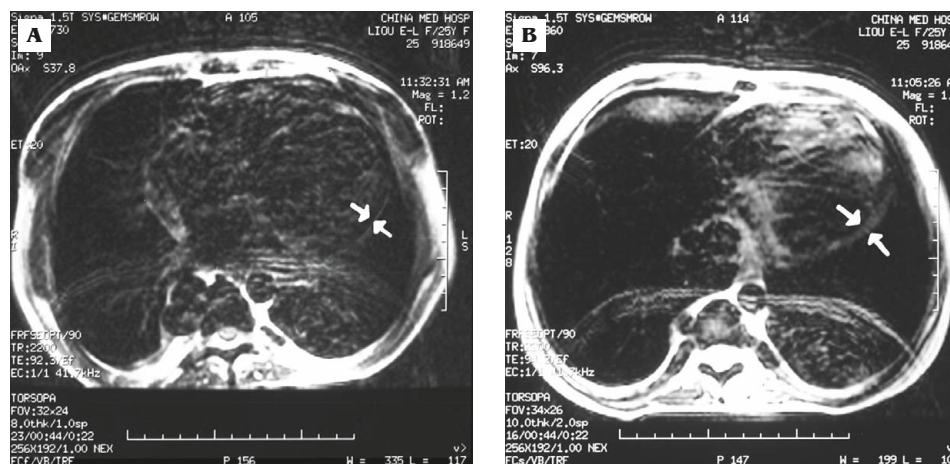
Magnetic resonance imaging of a patient's heart: (A) before combined therapy, axial view of the heart shows a decrease in signal intensity (SI) in the myocardium, suggesting substantial iron deposition (between arrows); (B) 13 months after combined therapy, marked recovery of SI suggests depletion of iron deposition (between arrows). Reprinted with permission from reference 23.
